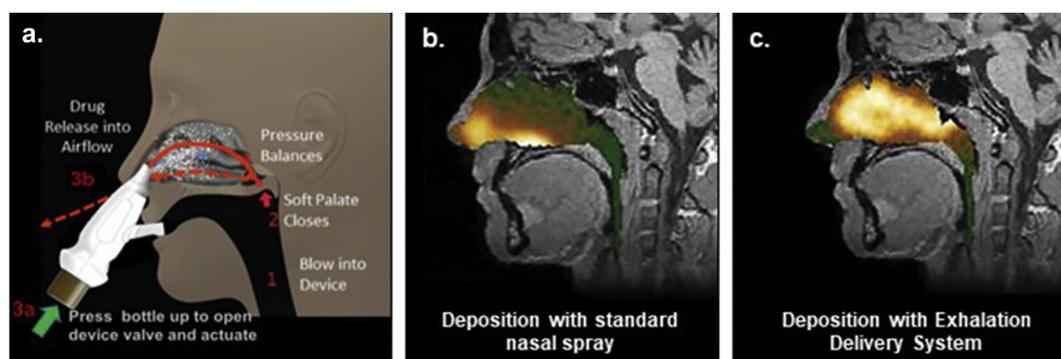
A, Exhalation delivery system (EDS) mechanism. Nasal deposition with convention device (B) and with the EDS device (C) by γ scintigraphy. γ Camera images after using a nasal spray without exhalation (B) or an Optinose EDS with exhalation (C). Both images are from the same healthy subject, taken 2 min after administration of radiolabeled solution and are representative of the overall findings from 211 images and 56 subjects. B and C, Reprinted with permission.^{13,22}
